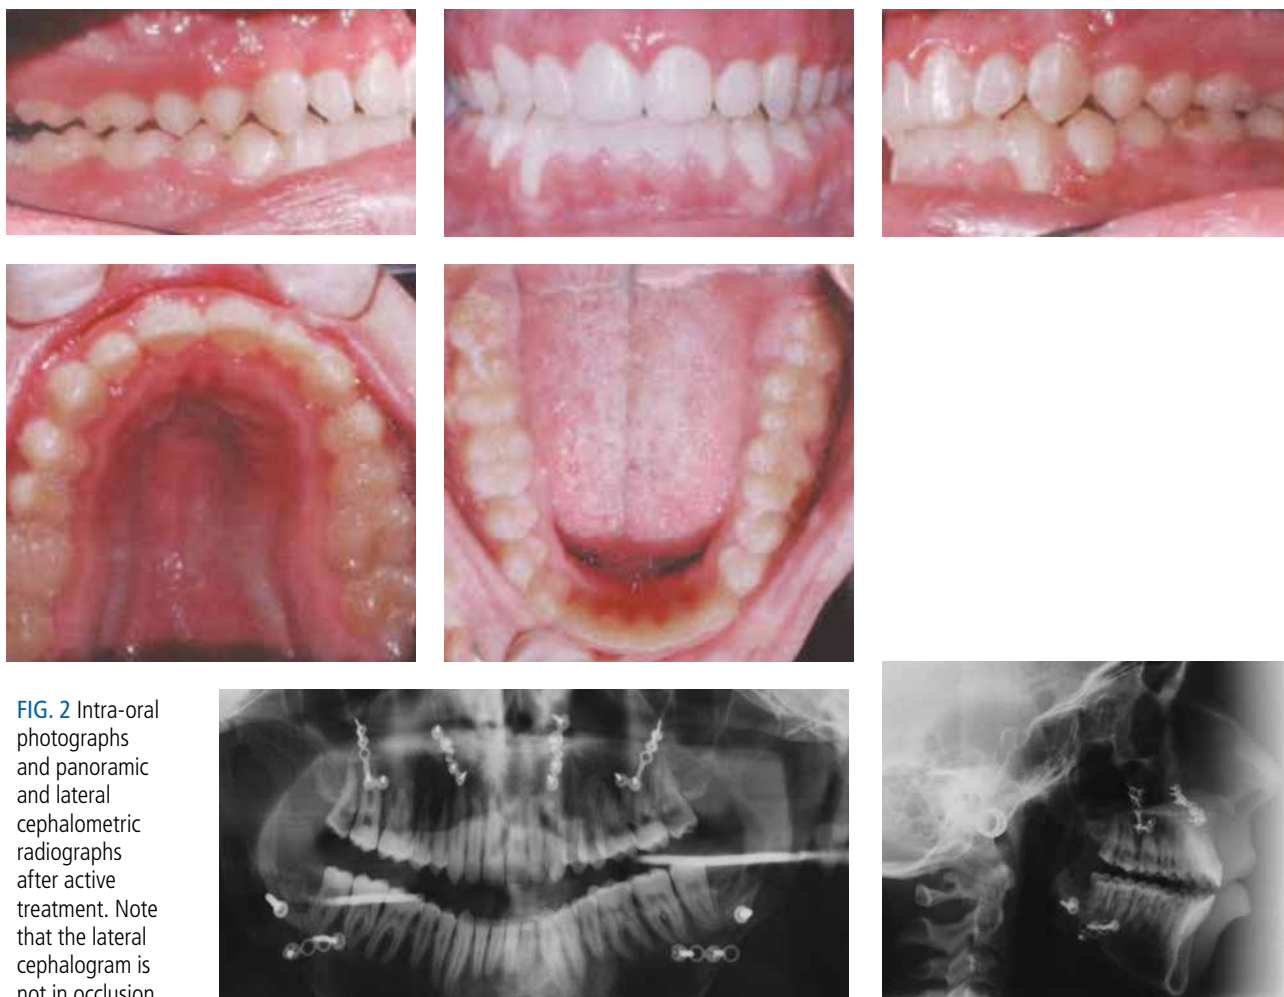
Intra-oral photographs and panoramic and lateral cephalometric radiographs after active treatment. Note that the lateral cephalogram is not in occlusion.
